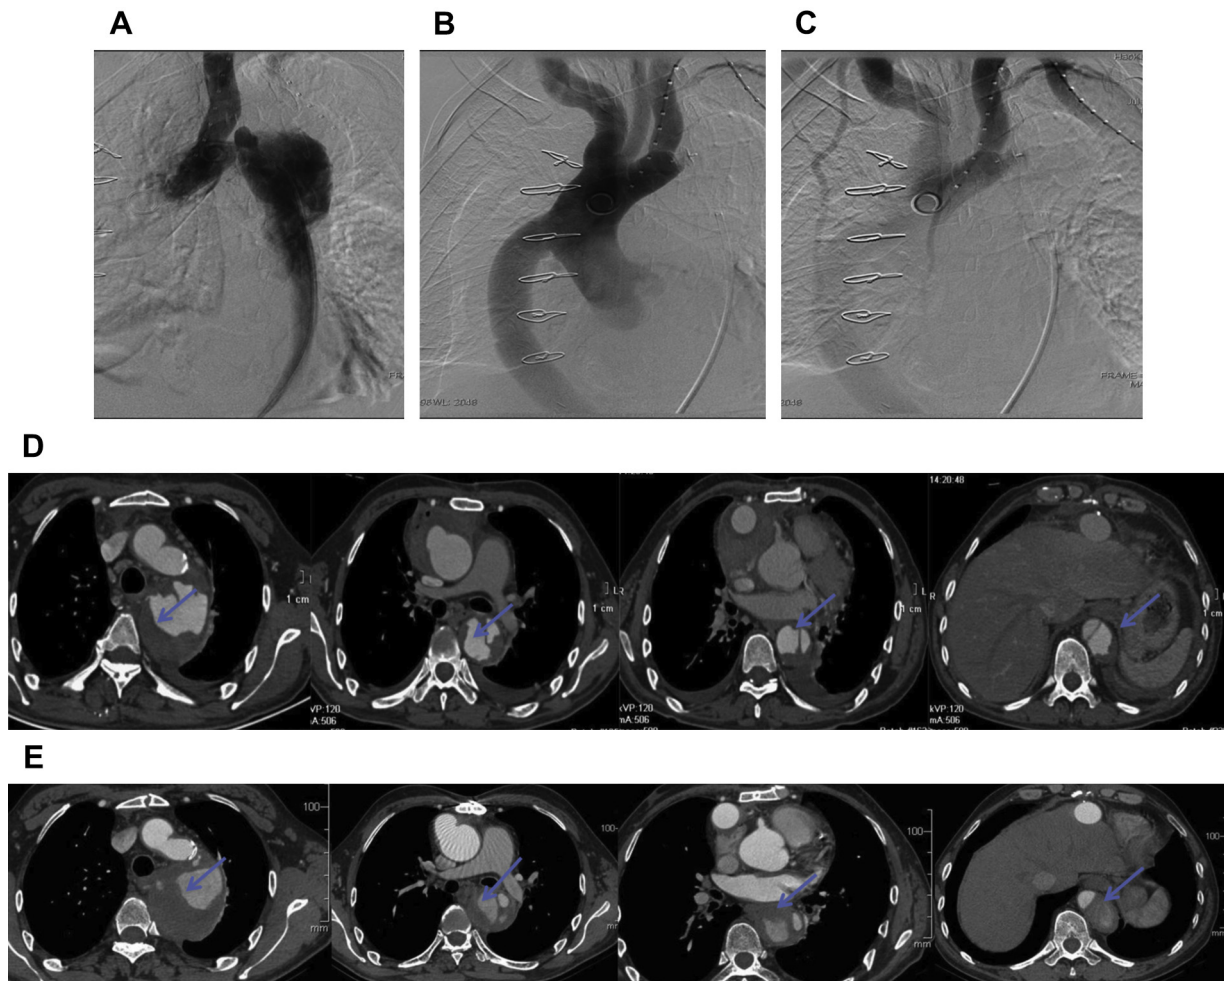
A, Preintervention aortography demonstrated the coarctation was discrete and the dissected artery was distal to the coarctation. B, Postinterventional aortography showed the patency of the bypass graft. B and C, The thoracic descending aorta was completely excluded from the ascending aorta. Postoperative computed tomography angiography at (D) 3 days and (E) 6 months demonstrated dynamic change of the partial thrombosis in the false lumen (arrows).
